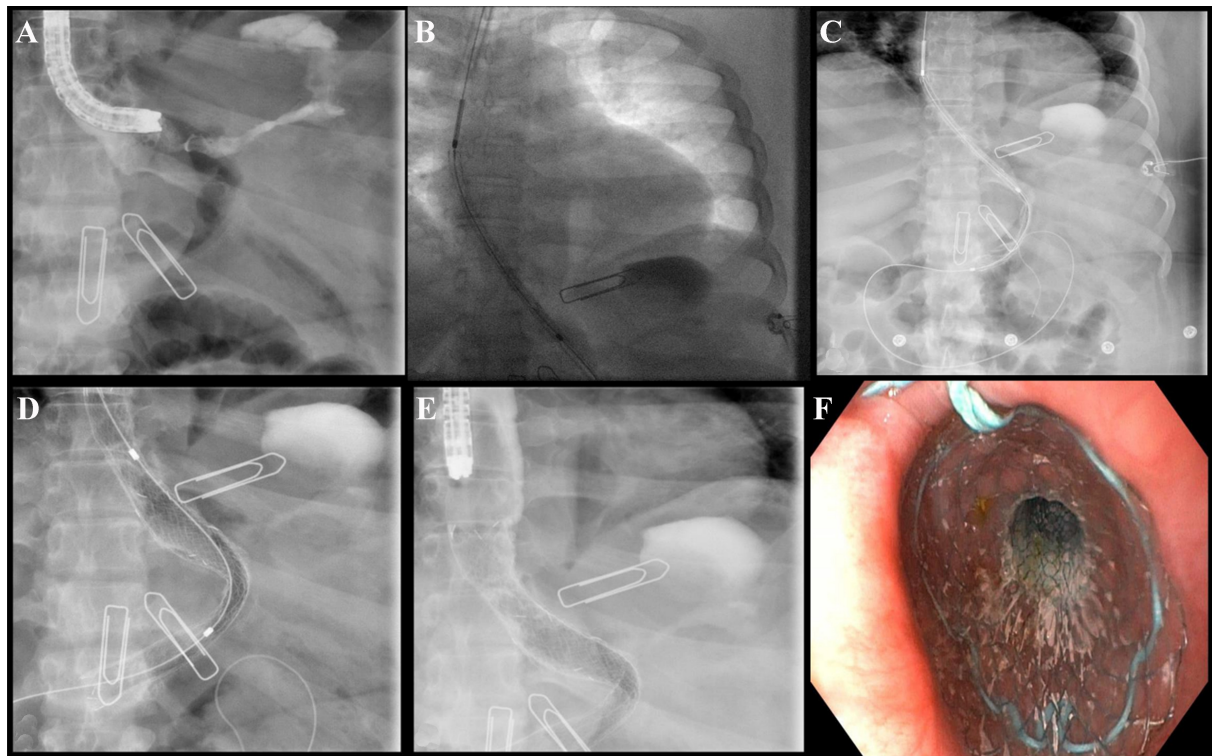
SEMS placement. (A) Fluoroscopy image demonstrating contrast extravasation following SG; (B) Radiographic view of external marker placement and guidewire insertion into the gastric lumen; (C) Fluoroscopic visualization of stent progression along the guidewire; (D) Stent expansion during deployment; (E) Endoscopic advancement post-stent placement; (F) Endoscopic visualization of the fully deployed stent *in situ*. SEMS: Self-expandable metal stents; SG: sleeve gastrectomy.
